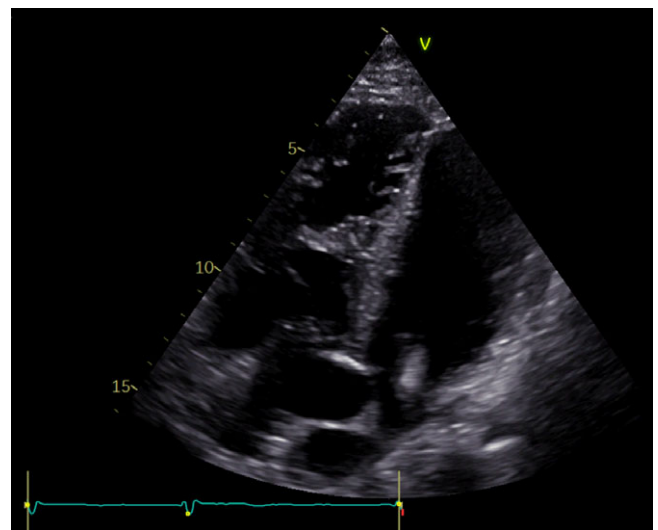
Echocardiographic follow-up.
